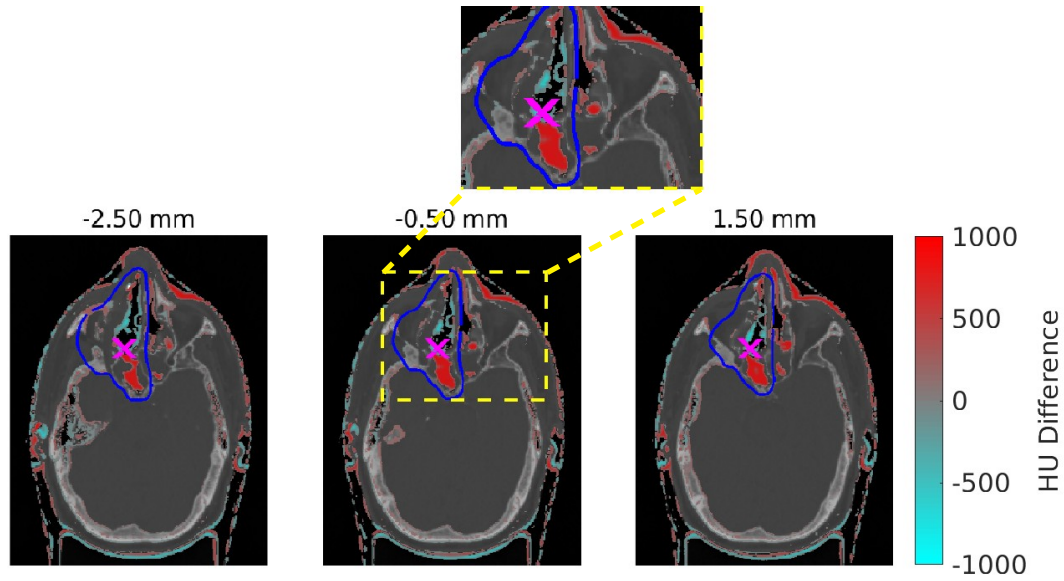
Anatomical changes between the planning and follow-up CTs, taken 12 days apart, are shown based on HU differences and superimposed on the planning CT. The three images represent 1 mm-thick axial CT slices spaced 2 mm apart, capturing the patient's anatomy and changes over a 5 mm span. Slice positions relative to the isocenter are indicated above each image.
